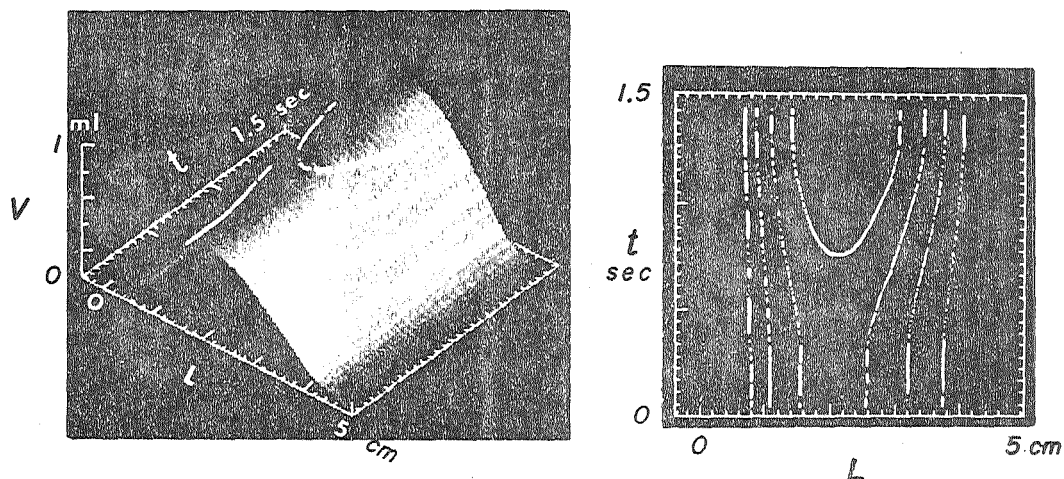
Computer generated spatial versus time displays of the regional volume $V(L, t)$ of a balloon. The data were determined from a biplane roentgenogram recorded on videotape during injection of 20 ml of roentgen contrast medium into balloon suspended in water. The left panel is an oscilloscopic display of the volume of 0.5 mm thick cross sections of the balloon (in ml on the Z axis) plotted against the position of these sections from inlet to tip (in cm on the X axis) and against time from the onset of the injection (in seconds on the Y axis).
